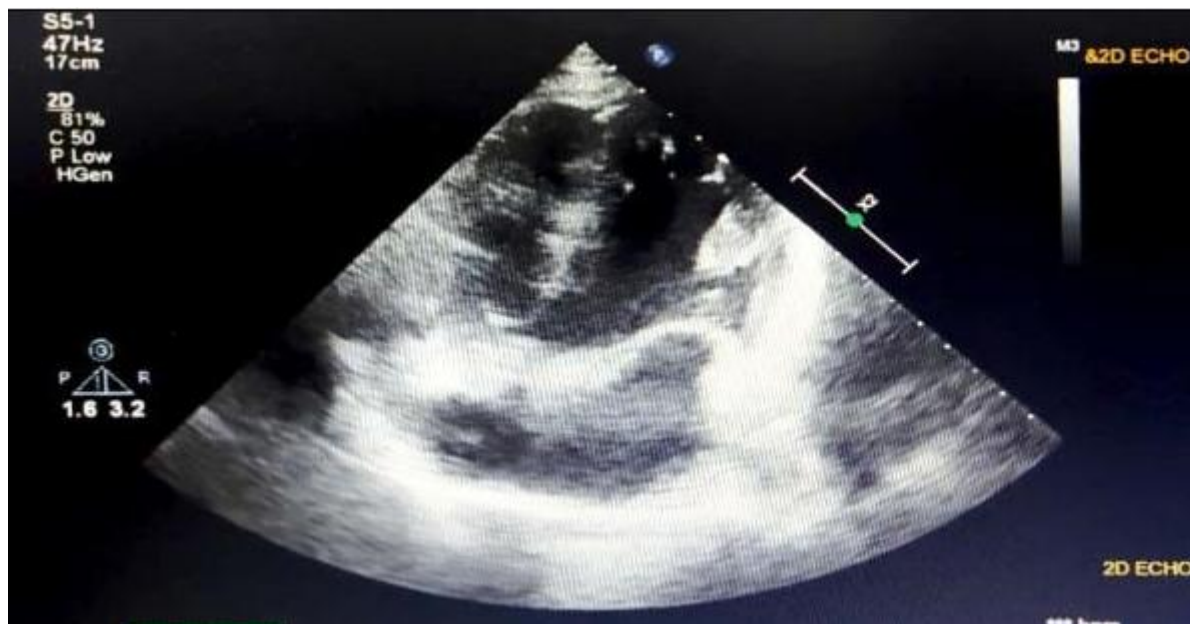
(b): Echocardiogram showing normal results post surgery
